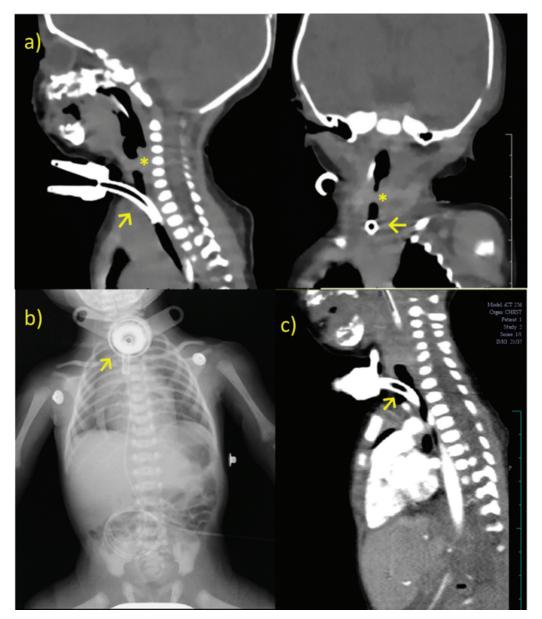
Postnatal X-ray and CT of fetuses who underwent EXIT tracheostomy. (a) Case 8—sagittal and a coronal section on CT with a tracheostomy tube in situ (yellow arrow) and yellow asterisk showing the atretic segment, (b) Case 9—X-ray showing the tracheostomy tube in situ (yellow arrow), and (c) Case 9—CT showing the tracheostomy tube in situ (yellow arrow). CT, computed tomography; EXIT, ex utero intrapartum treatment.
